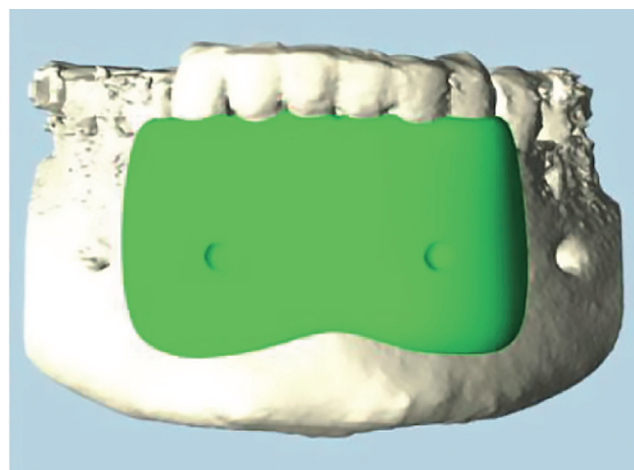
Bone block planning based on cone beam computed tomography (CBCT). The defect planning is divided into 5 regions (4 external and 1 internal). The position of the screws was taken into account in the planning
